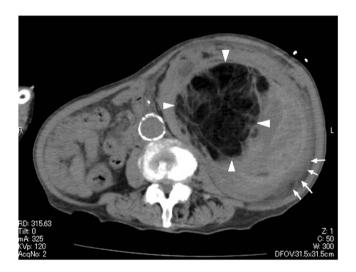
CT scan of the abdomen showing retroperitoneal hemorrhage (*short arrows*) and areas of fatty tissue (*arrow heads*).
